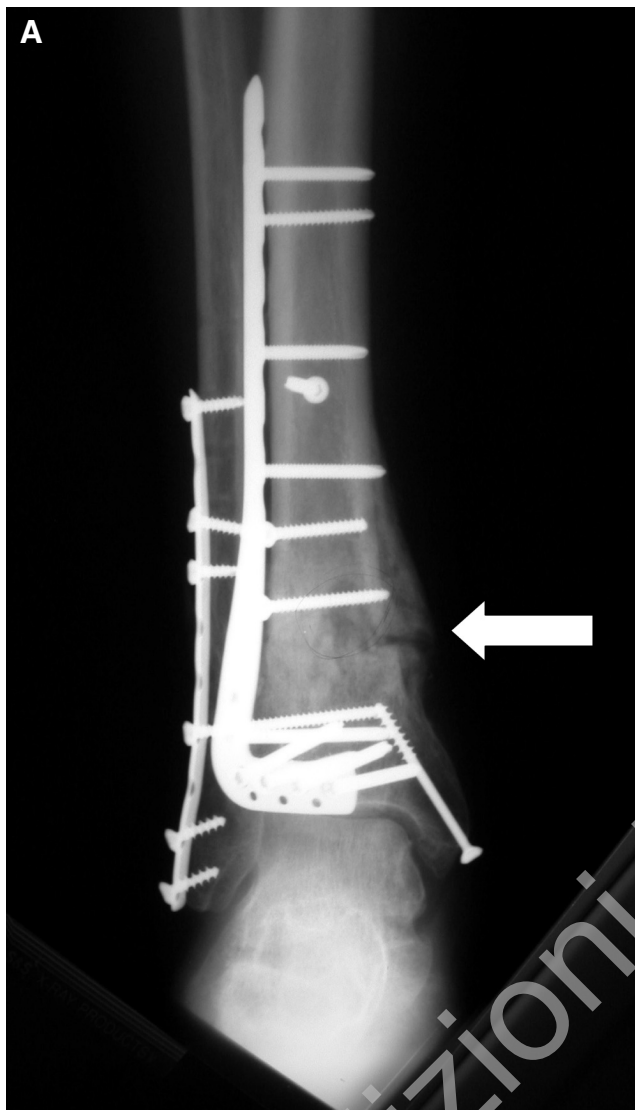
A. Anteroposterior radiograph of a 49 year old man with a nine months old tibial nonunion. The patient had undergone several attempts at operative fixation and grafting which included autologous iliac crest bone graft and recombinant human OP-1 (bone morphogenetic protein-7). An incomplete union is noted with radiolucency clearly visible approximately 4 centimeters proximal to the medial malleolus. B. Anteroposterior radiograph four months after bone marrow aspirate concentrate injection. Note complete healing of the nonunion site.
